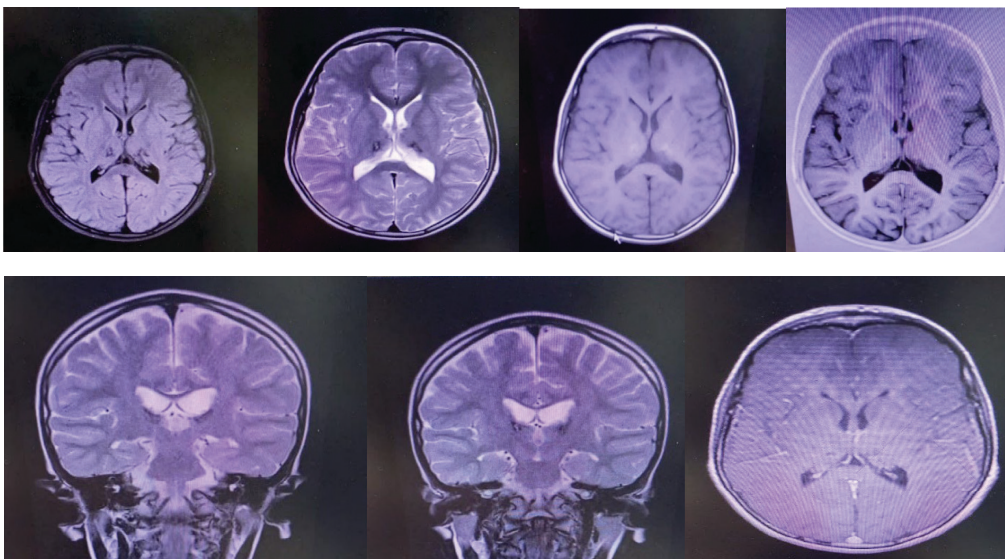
Brain MRI (without and with Gd+ DWT)
